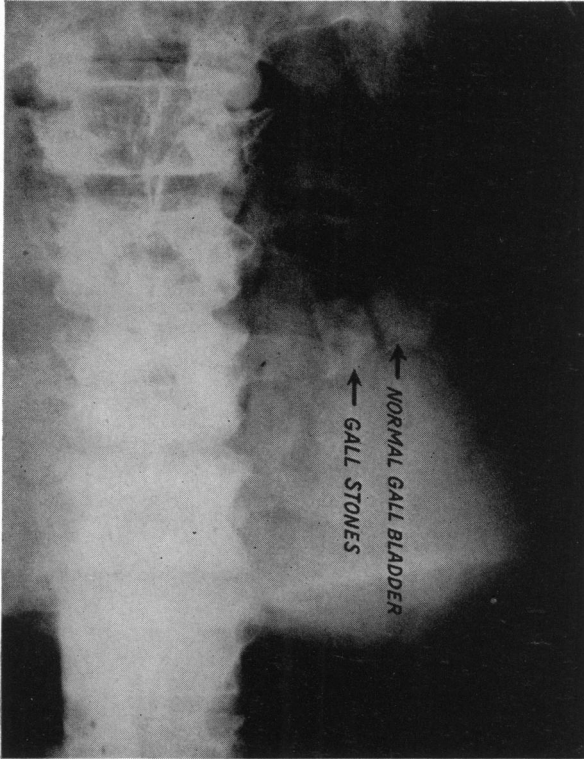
Roentgenogram showing a duplicate of the gallbladder—one containing calculi, the other apparently containing dye only.
